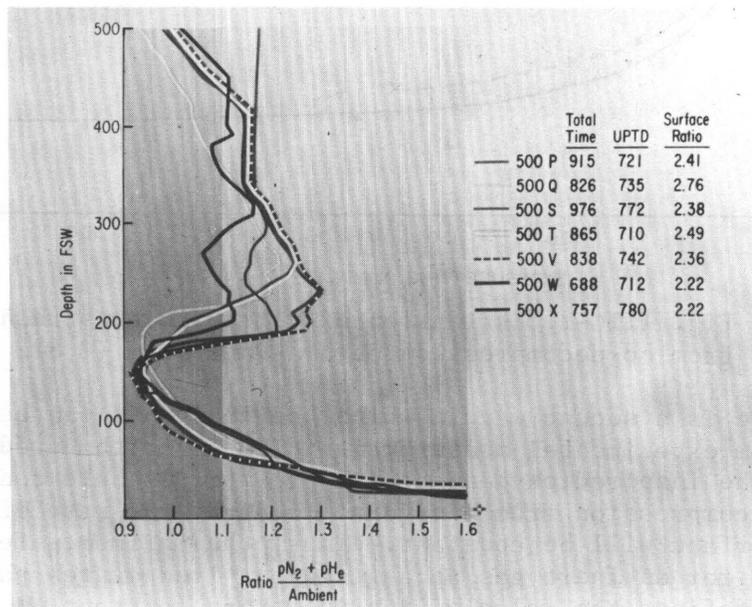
IIIG-4. Same plot as Fig. IIIG-3, for later dives (including X-ray).
